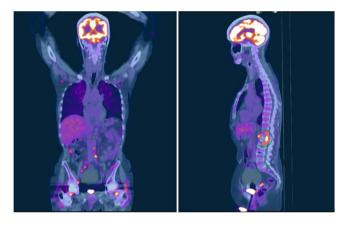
PET-CT coronal and sagittal slices, respectively.
